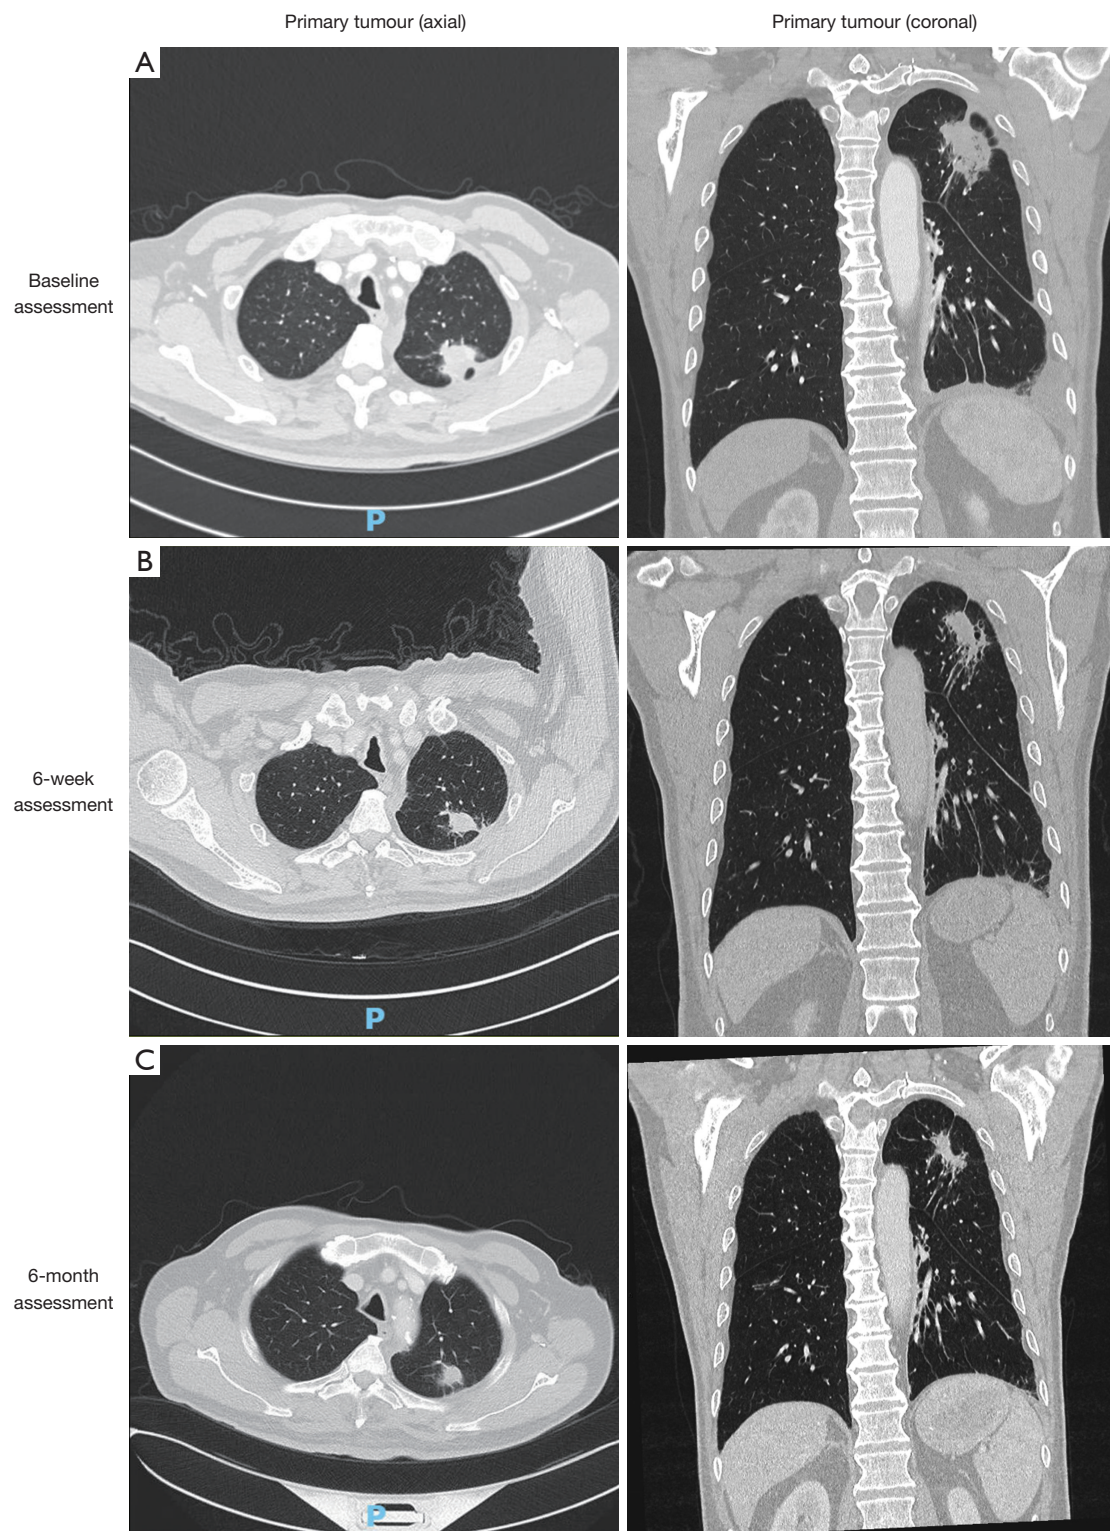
Chest CT scans. (A) Pre-treatment 3.6 cm primary left upper lobe lung cancer. (B) Response to treatment of the primary tumour (2.0 cm) at 6 weeks. (C) Further response of the primary tumour at 6 months (1.7 cm). CT, computed tomography.
